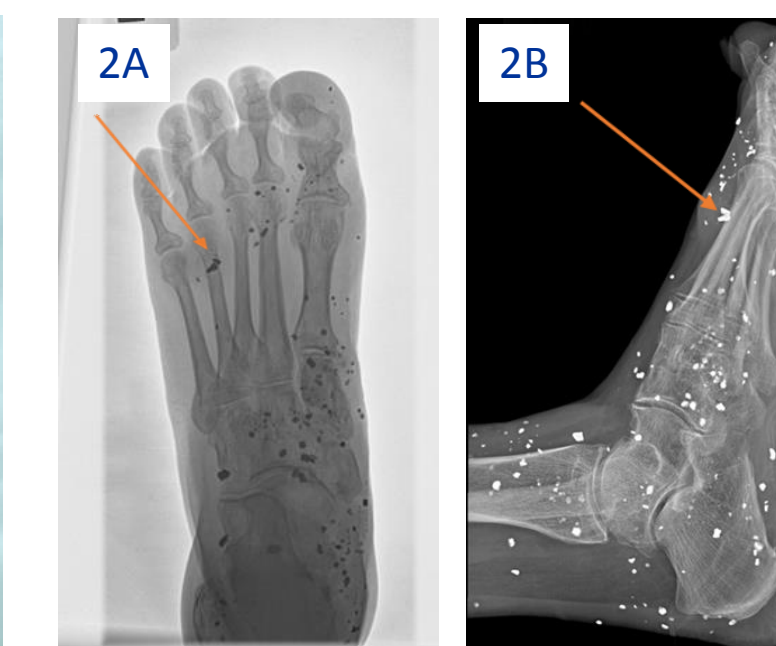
AP plain film radiograph
